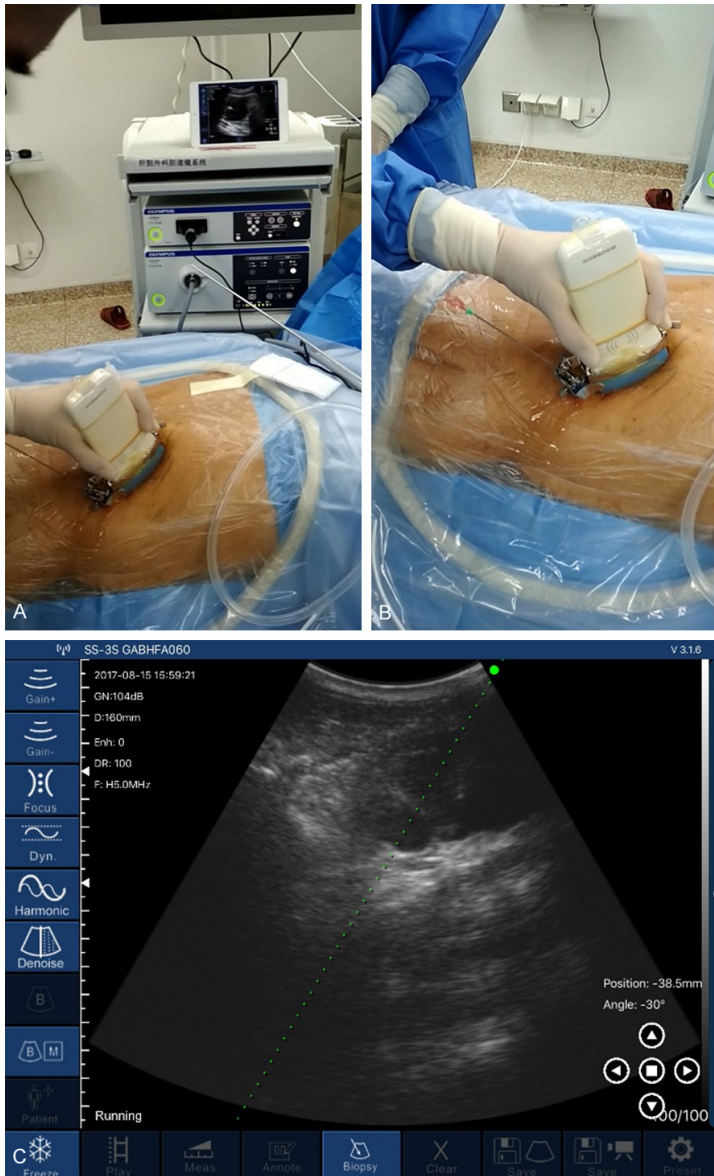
A. In the test group, the wireless probe (UProbe-2) was used to locate the target renal calyx in the pre-operatively predetermined puncture area; B. Clear urine flew out after the target renal calyx was punctured; C. The wireless ultrasound software application was operated by an iPad tablet to display the hydronephrosis image and calyceal puncture approach.
